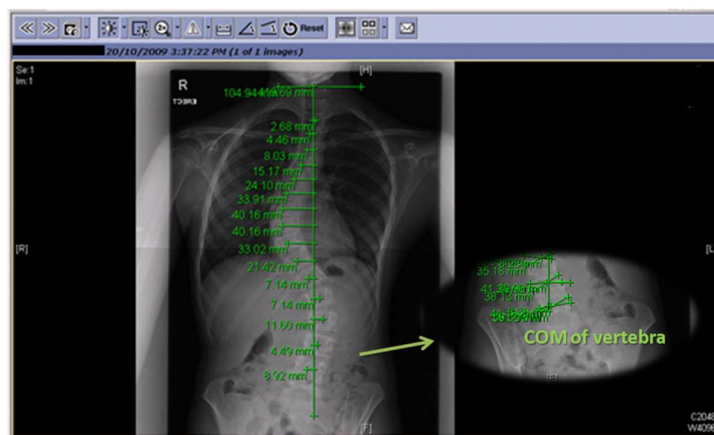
Location of the COM of the vertebrae in X-ray image
